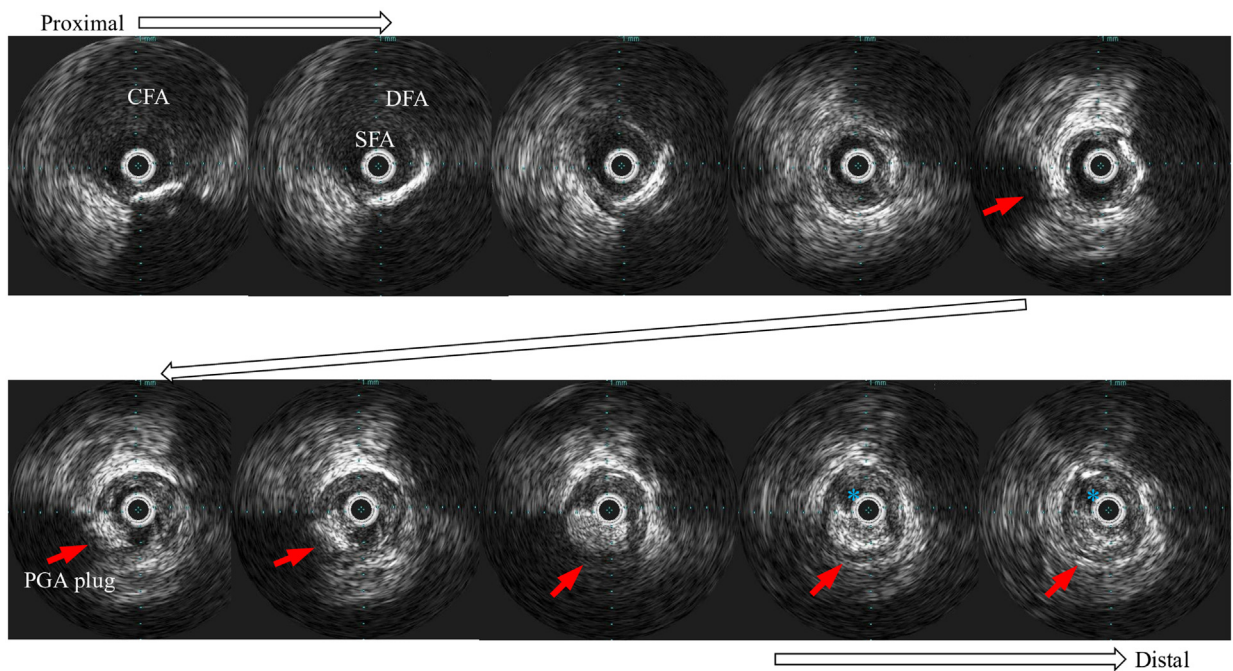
Intravascular ultrasound (IVUS) images. The high-density structure was crossing into the vessel (red arrows). This was the plug of EXOSEAL and narrowed the lumen of the proximal superficial femoral artery (SFA) (blue asterisk). CFA, Common femoral artery; DFA, Deep femoral artery; PGA, polyglycolic acid.
